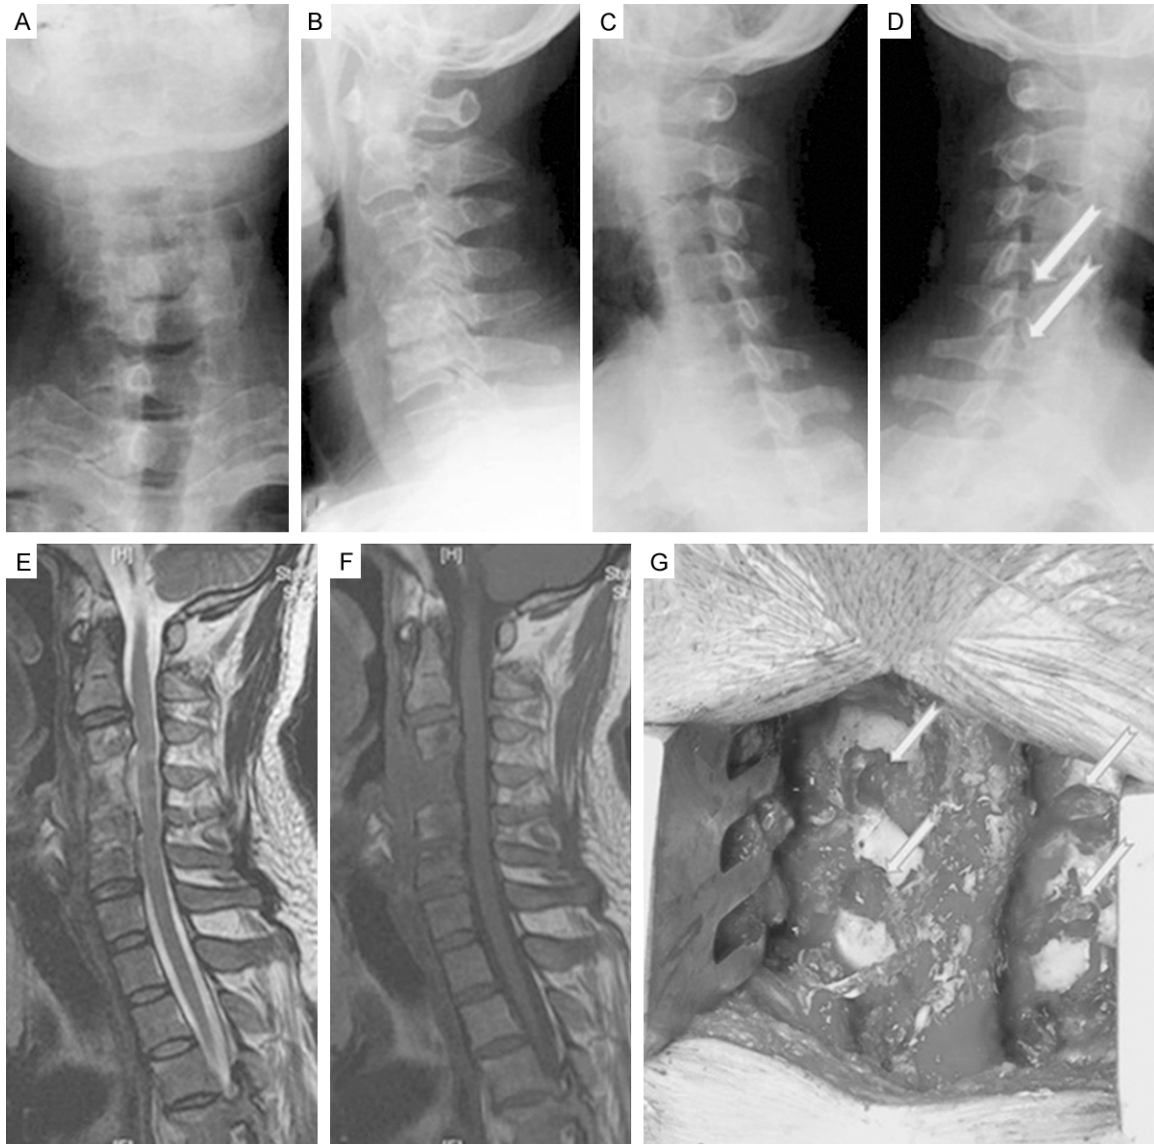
Patient's conditions 4 months after operation. A-F: The patient reported aggravated numbness and asthenia of both upper limbs; medical examination showed hypermyotonia of the four limbs, right upper limb muscle strength at level IV, left upper limb muscle strength at level III, bilateral lower limb muscle strengths at level IV+, and sensation disorders of both upper limbs; and X-ray and MRI re-examination exhibited cervical lordotic curve loss in the operative region and slight stenosis of the right intervertebral foramen between C5 and C6 but without apparent spinal cord compression. G: Considering that foraminal stenosis and root compression might be caused by intervertebral height loss, posterior C5-6 foraminotomy was performed.
